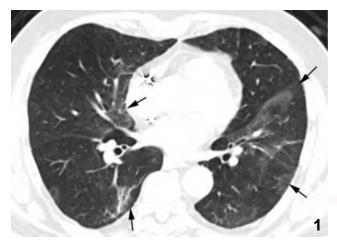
Axial CT demonstrating patchy, nonspecific ground glass opacities (arrows) in a patient who had started thalidomide therapy for multiple myeloma three weeks prior.
